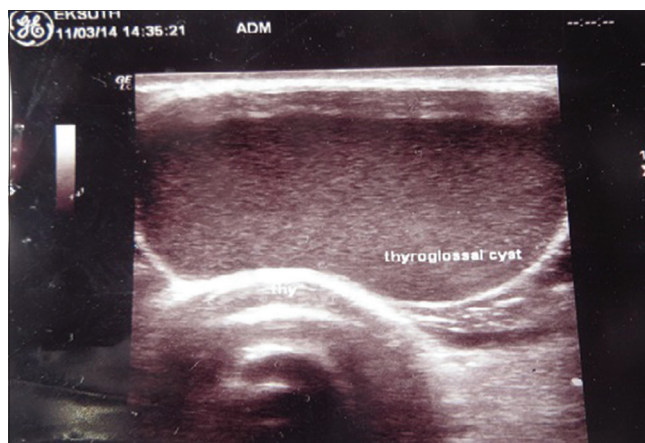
Ultrasonography scan showing a thick walled cystic centrally located anterior neck mass containing medium level internal echoes consistent with a thyroglossal cyst
